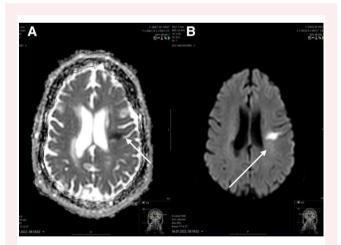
Magnetic resonance imaging of the brain, axial DWI (A) and ADC sequence (B). Diffusion restriction on the left in the corona radiata extending into the precentral gyrus with corresponding signal reduction in the ADC maps and mild hyperintensity in the T_2 sequences. Hemosiderin deposition in the right thalamus indicative of a past haemorrhage. Non-specific peri- and paraventricular white matter gliosis, most likely of microangiopathic origin. Multiple lacunar defects in the basal ganglia region on both sides. Assessment: Acute ischaemia in the left corona radiata extending into the precentral gyrus. No haemorrhagic transformation. Post-haemorrhagic defect in the right thalamus.
